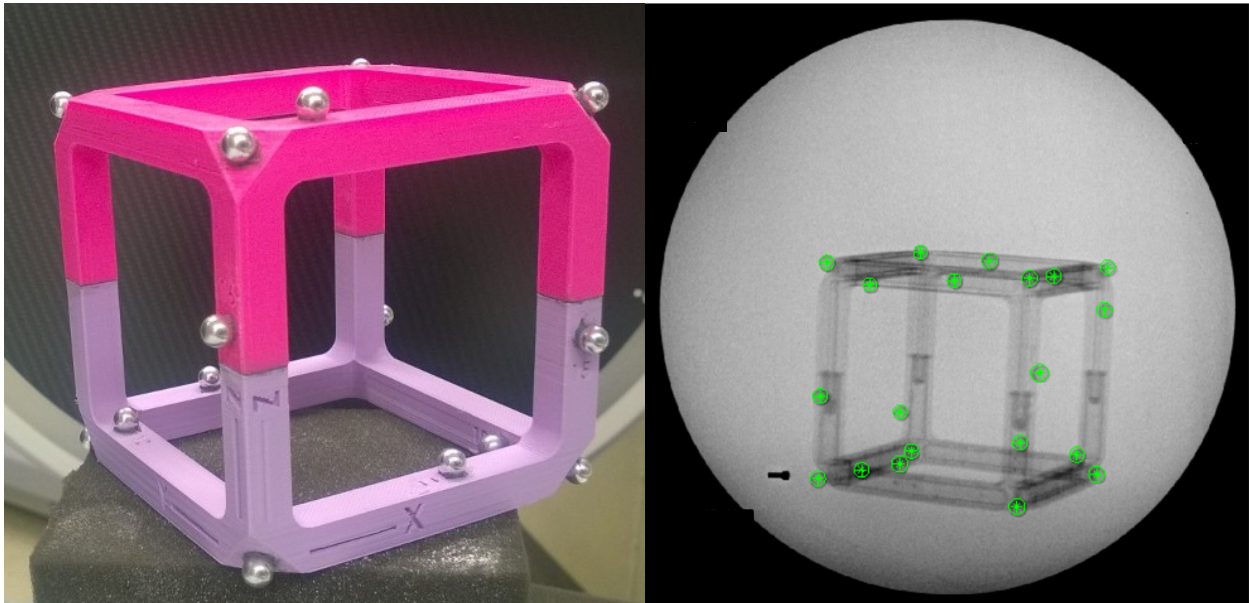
a) The calibration cube with 20 radiopaque spheres used to create the virtual camera environment. Each sphere was labeled with its location to easily match to the bi-planar images taken during C-arm environment calibration. b) An x-ray of the calibration cube with all radiopaque sphere locations identified within the image.
